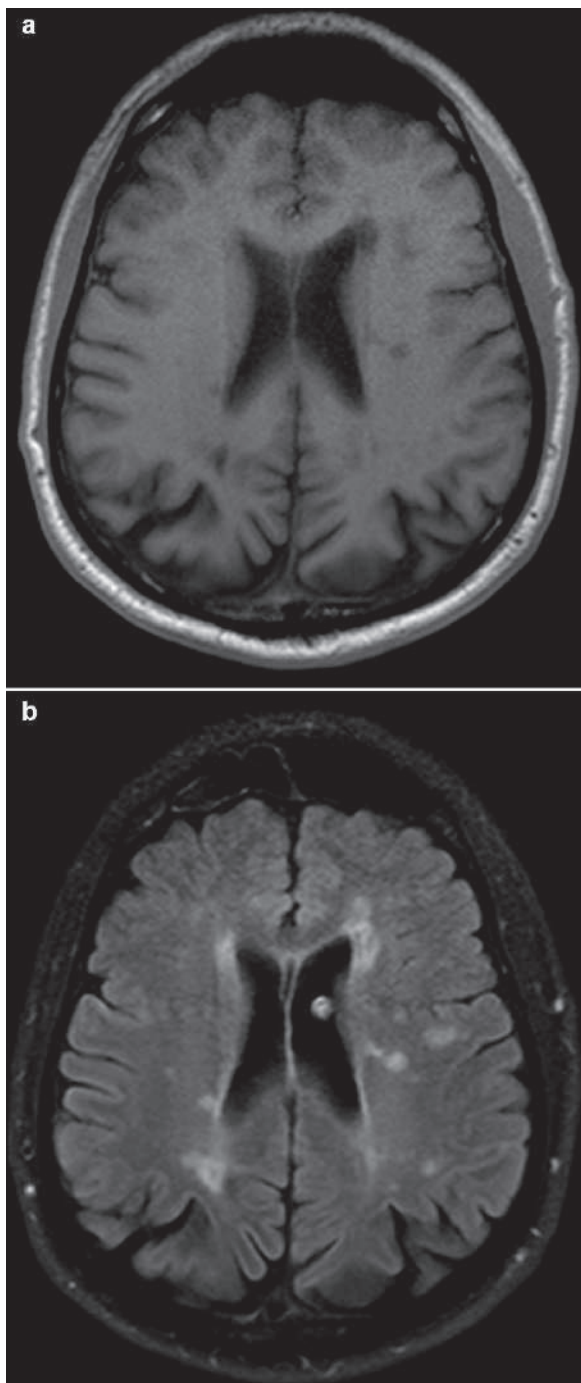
Axial T1W (a) and FLAIR (b) brain MRI in a patient with MS shows classical periventricular white matter lesions (plaques)
